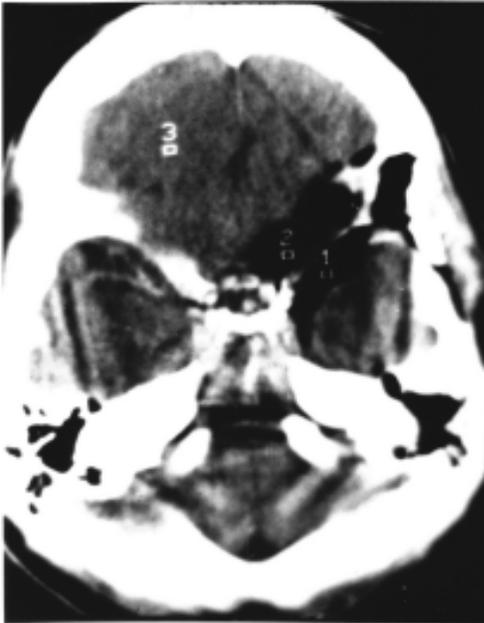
Postoperative CT scan with contrast obtained 3 months after surgery, showing the presence of omental tissue over the left sphenoid ridge, optic chiasma, carotid bifurcation and anterior perforated space, in the same patient of figure 1.
